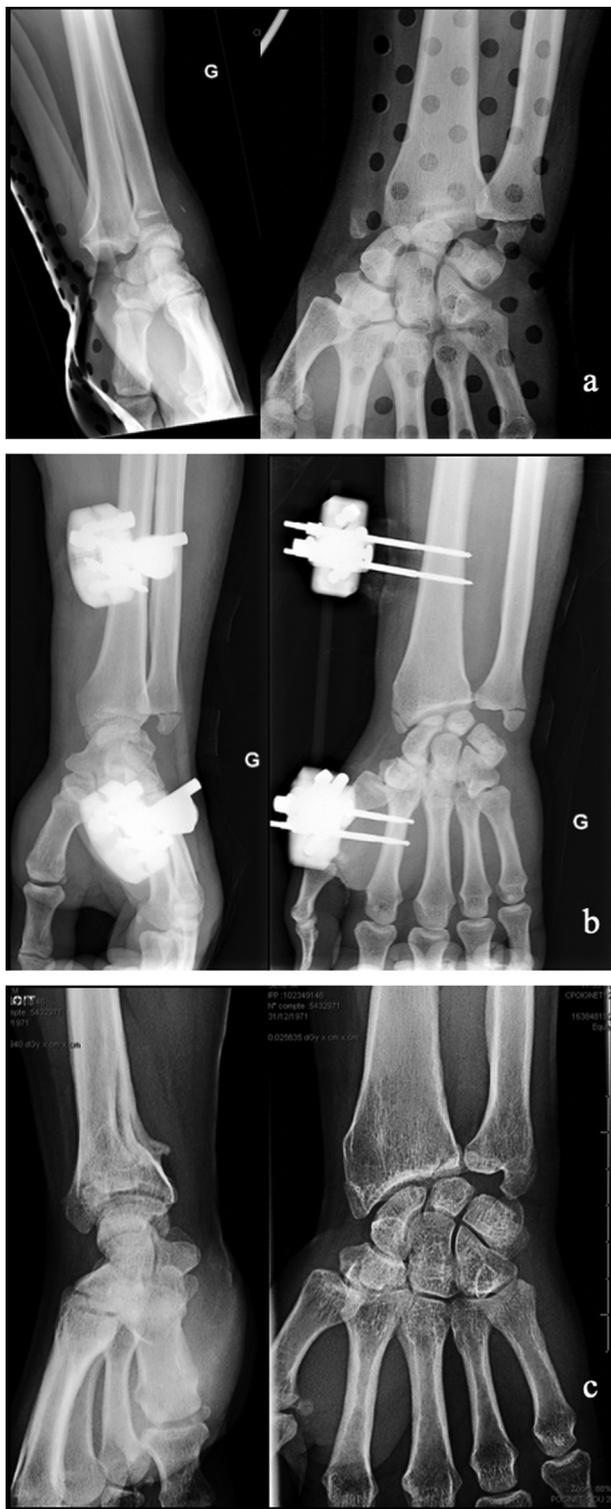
Example of 47 year-old patient: a) Dumontier [4] type 1 radiocarpal dislocation; b) Postoperative radiograph; c) Wrist X-ray at 48 months.
